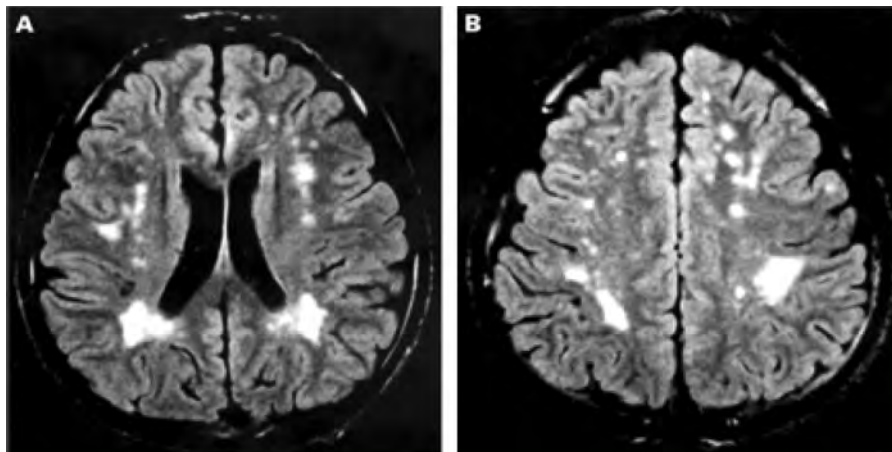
Toluene exposure. MRI T1W showing extensive white matter change.
